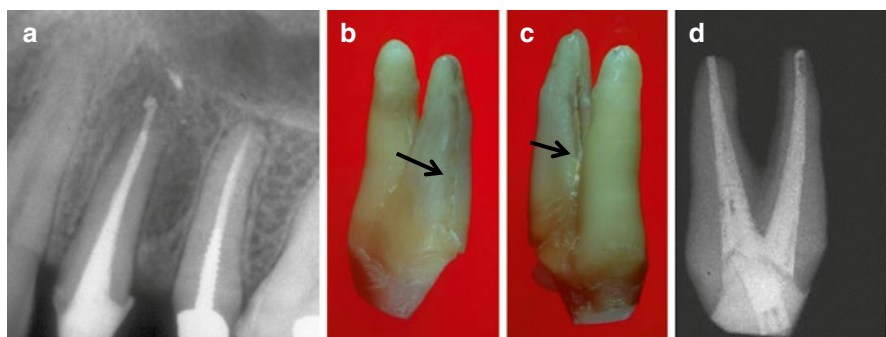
A periapical radiograph of an endodontically treated maxillary premolar. (a) A large lateral radiolucency can be seen in the mesial aspect. Few exacerbations occurred in recent years, and a deep buccal probing was noted in midbuccal area. The extracted tooth is showing the complete VRF in the buccal root. (b, c) The *black arrows* are pointing at the VRF. The bench periapical radiograph of the extracted tooth (d) is showing the large amount of dentin removed in the buccal root
